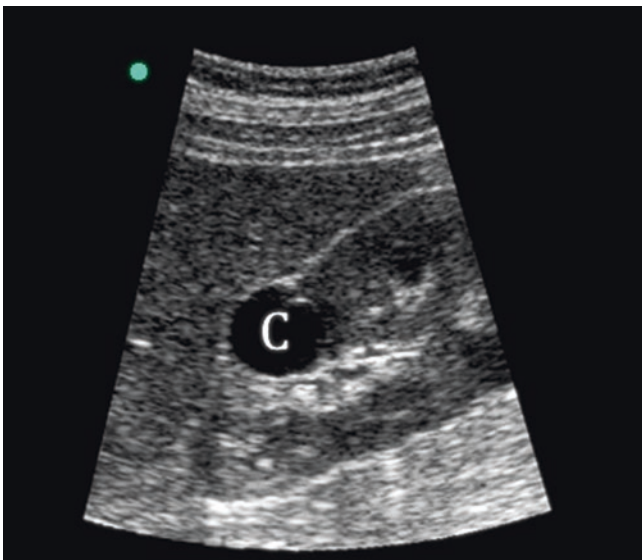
Ultrasound image of a renal cyst (C) in the longitudinal plane. Simple cysts are smooth and oval-shaped, with a well-circumscribed border and posterior acoustic enhancement. Their center is anechoic and without septations. Cysts that do not fulfill these criteria are categorized as complex cysts. (Image courtesy of Bret Nelson.)
